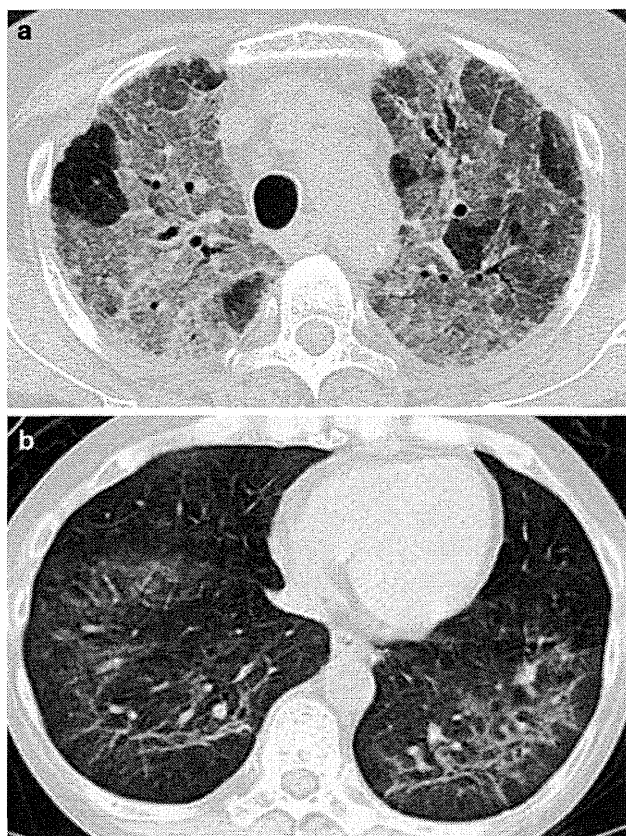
Representative thoracic computed tomography findings of rheumatoid arthritis patients who developed *Pneumocystis jirovecii* pneumonia while receiving adalimumab. a Ground-glass opacity (GGO) with sharp demarcation by interlobular septa (type A) (patient 12). b Inhomogeneous GGO without obvious demarcation by interlobular septa (type B) (patient 1)
